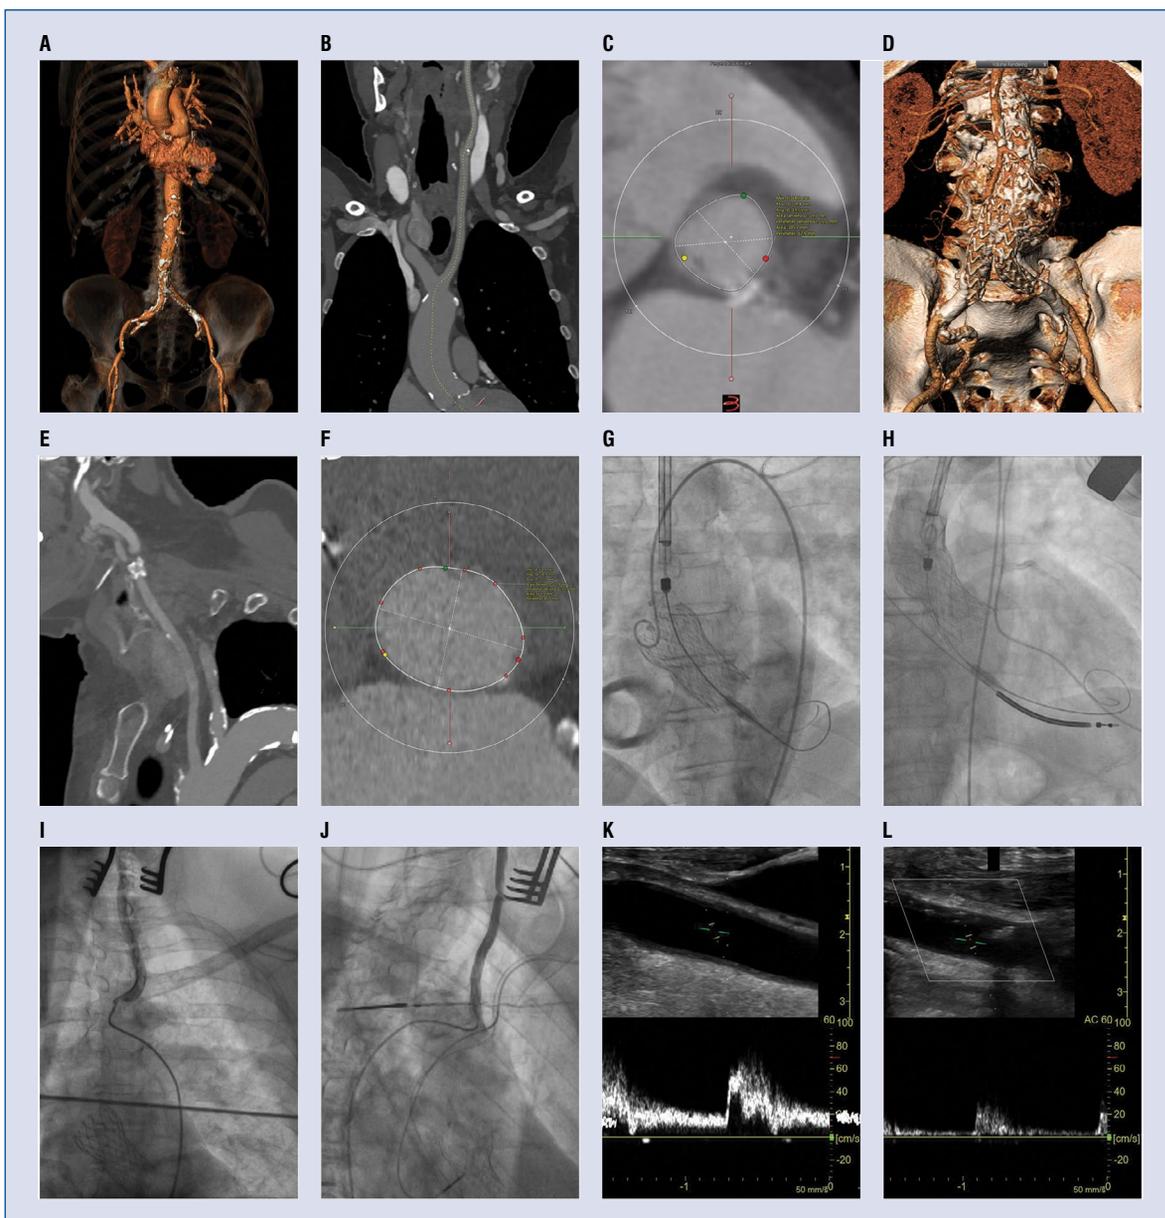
Periprocedural imaging. A. Three-dimensional (3D) reconstruction image of the multislice computed tomography (MSCT) of the iliofemoral arteries and abdominal aorta in Patient 1; B. Image of the MSCT of the left carotid artery and aortic arch in Patient 1; C. Image of the MSCT dimensions of the aortic annulus in Patient 1; D. 3D reconstruction image of the MSCT of the iliofemoral arteries and abdominal aorta in Patient 2; E. Image of the MSCT dimensions of the aortic annulus in Patient 2; F. Image of the MSCT of the left carotid artery and aortic arch in Patient 2; G. Implanted aortic valve prosthesis in Patient 1; H. Image of the implanted aortic valve prosthesis in Patient 2; I. Image of the control left common carotid artery (LCCA) arteriography in Patient 1; J. Image of the control arteriography of the LCCA in Patient 2; K. Image of the control Doppler ultrasonography of the LCCA in Patient 1; L. Image of the control Doppler ultrasonography of the LCCA in Patient 2.
